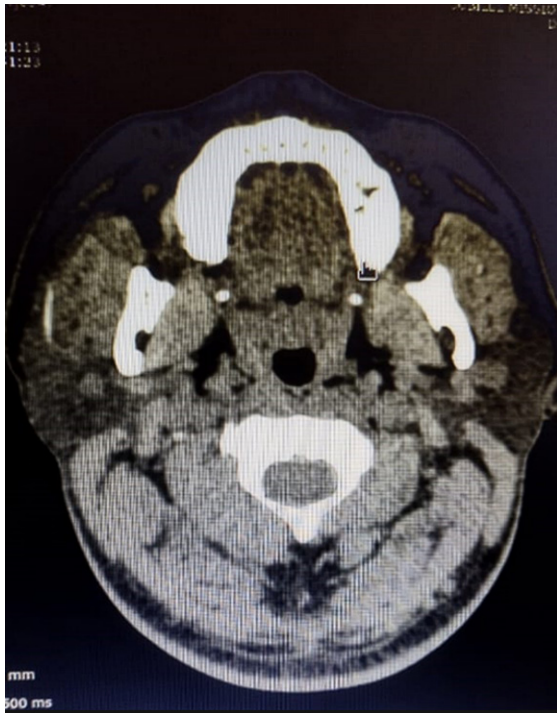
CT, axial cut across parotid gland , showing linear hyperdense structure
